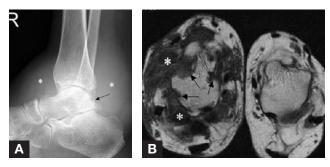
(A) Lateral radiograph of the right ankle shows a large, dense ankle effusion (asterisks) with suggestion of articular erosions (arrow). (B) Axial proton density images of both ankles in the same patient show prominent diffuse intra-articular soft-tissue masses (asterisks) with multiple erosions (arrows) in the right ankle. Normal left ankle is shown for comparison.
